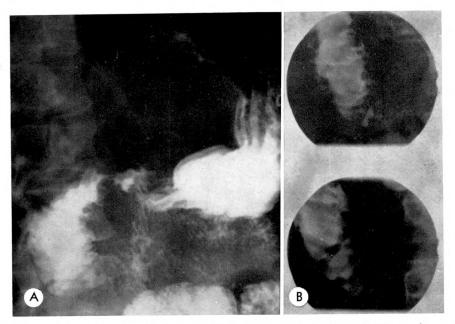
(A) Barium in the dilated duodenum partly obscures mucosal edema, but it can be seen on roent-genograms (B) made with the compression cone. Acute pancreatitis was diagnosed on the basis of clinical and roentgenologic findings in this patient.
